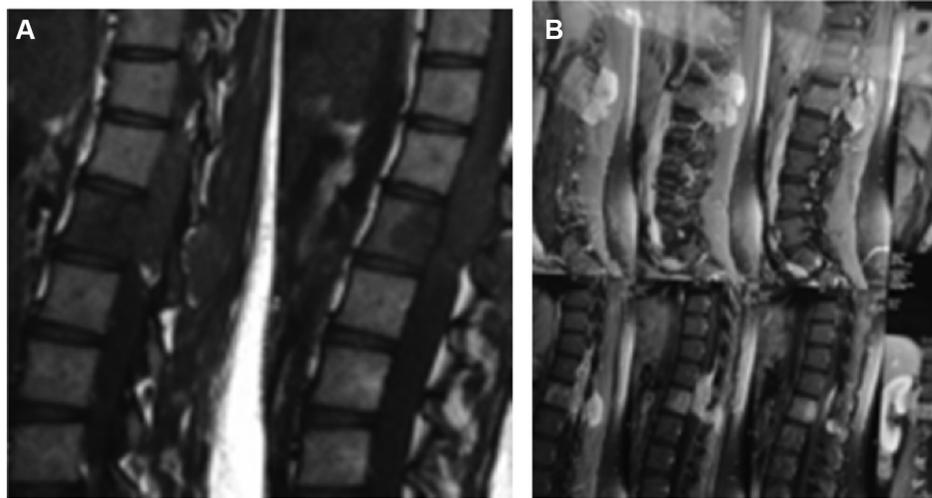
Contrast enhanced MRI showing an extensive tumour mass compressing the conus medullaris. (A) and (B) represent two different cut section of MRI in sagittal plane. MRI = magnetic resonance image.
